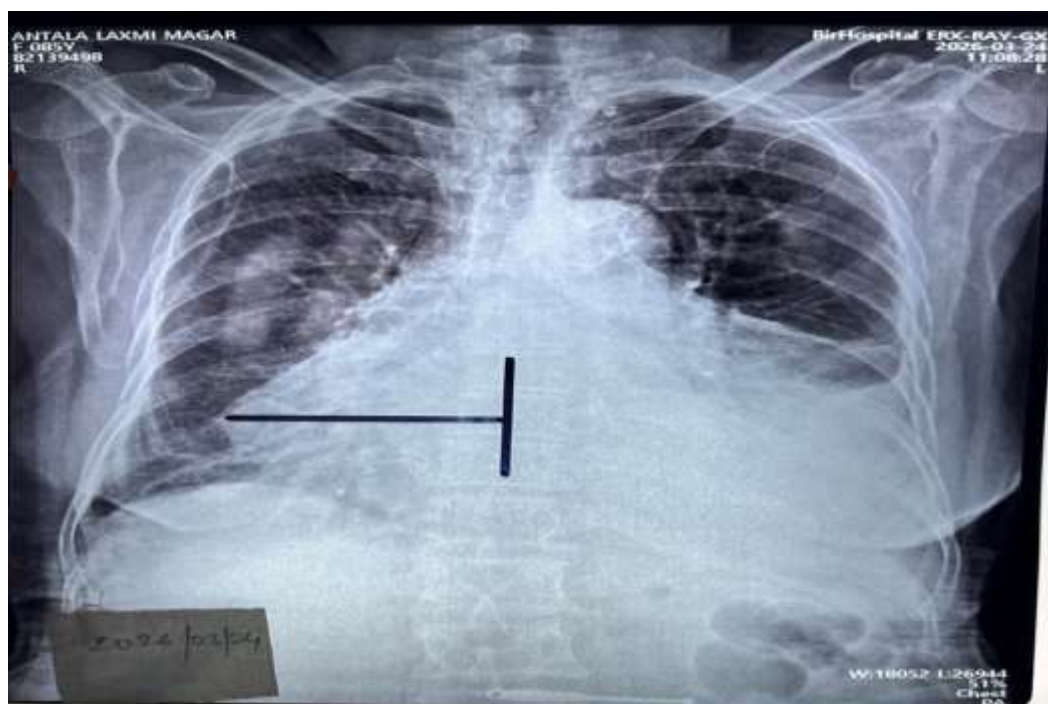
Posterior-anterior (PA) chest radiograph taken at presentation demonstrating a moderate left-sided pleural effusion with blunting of the left costophrenic angle, alongside marked cardiomegaly.
